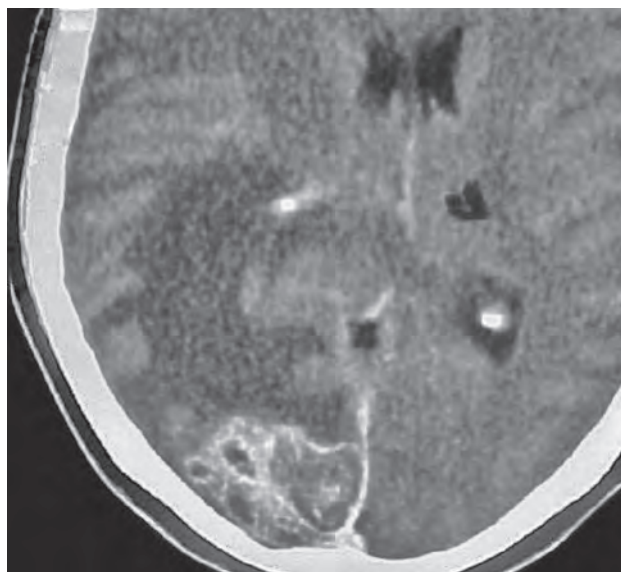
Contrast CT scan of the brain showing enhancing tuberculoma in the right occipital lobe which is surfacing and minimal shift of the posterior falx to the left due to mass effect
